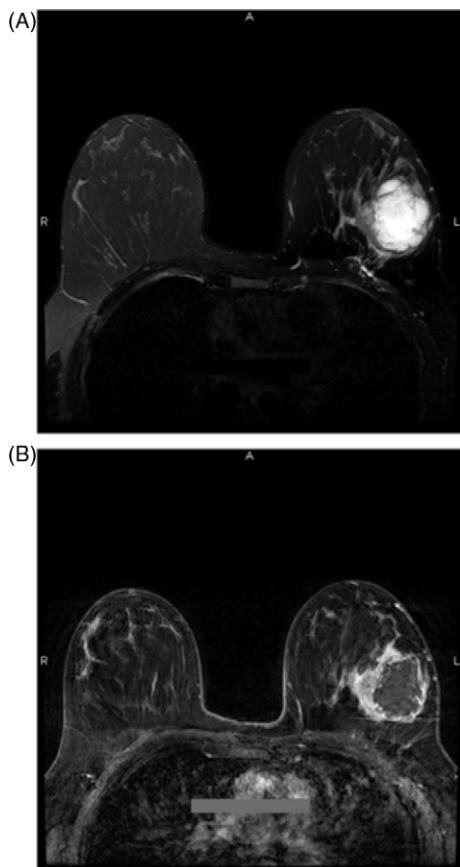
(A) MRI T2-weighted image shows a large circumscribed mass with internal high-signal intensity and edema and inflammatory changes noted to extend to the chest wall. (B) MRI post contrast T1-weighted image shows a large predominantly cystic complex mass with thick enhancing septations and thick enhancing peripheral rim.
